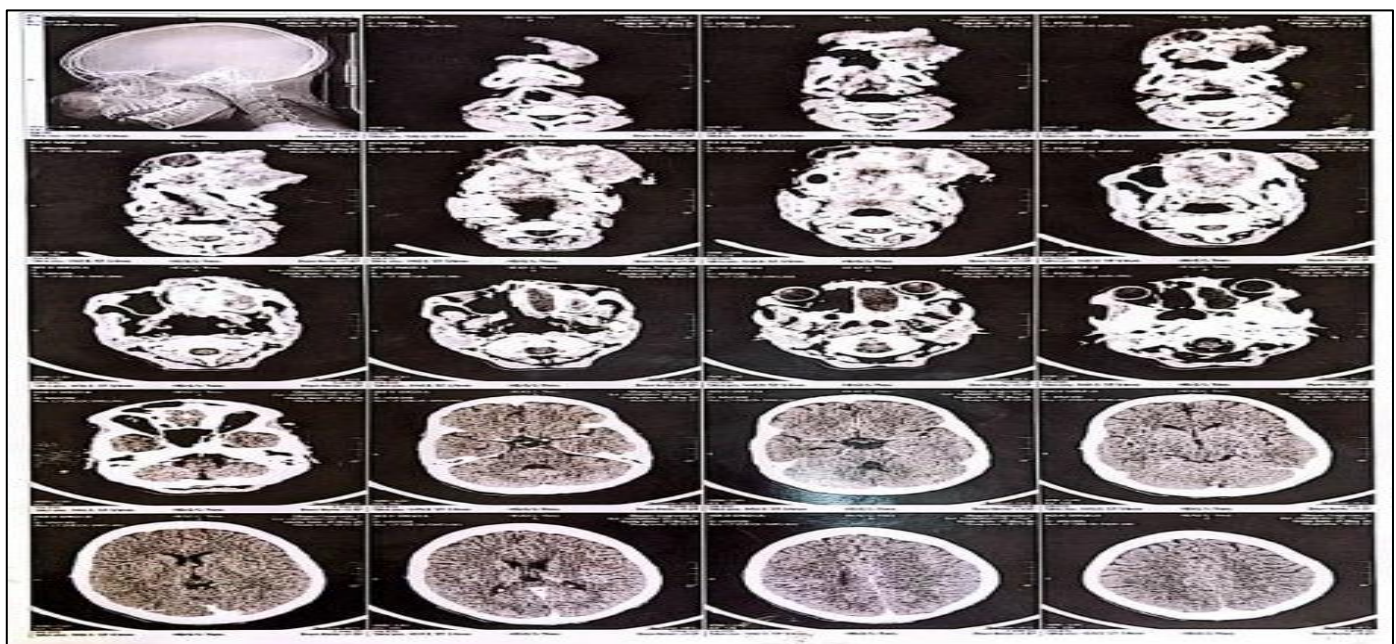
Multiple Axial Cuts of the CT-Scan Showing Lobulated Soft Tissue Mass Involving the Left Maxilla, Obliterating the Left Maxillary Sinus and Nasal Cavity with Bone Destruction
